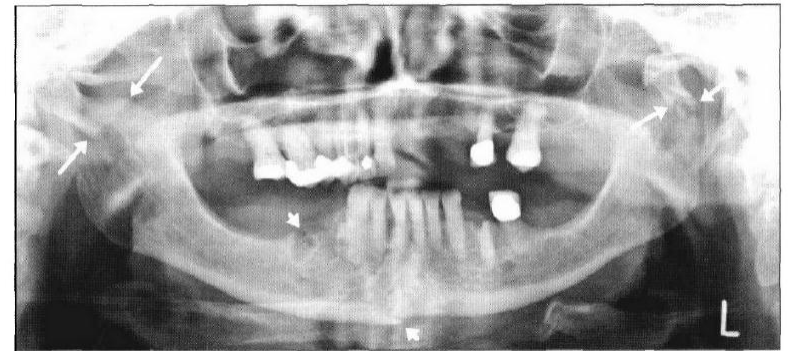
Orthopantomogram (OPG) radiograph demonstrating bilateral condylar fractures (long arrows) and right parasymphiseal fracture (short arrows)
